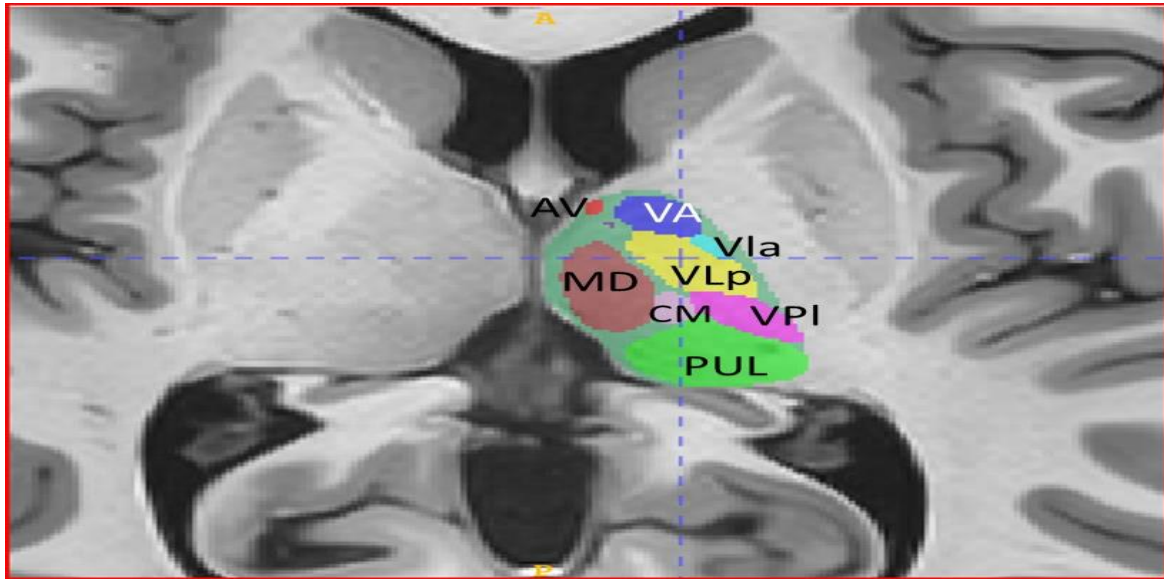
Thalamic nuclei segmentation on Axial MRI.
